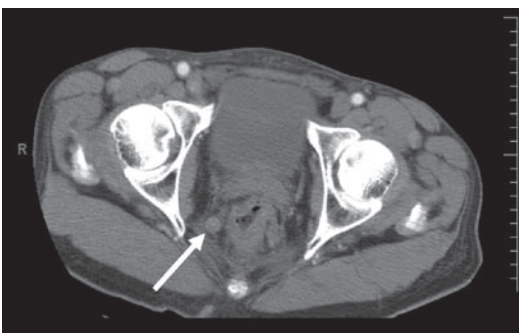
CT scan shows rectal mass with adjacent enlarged mesorectal node (arrow).
